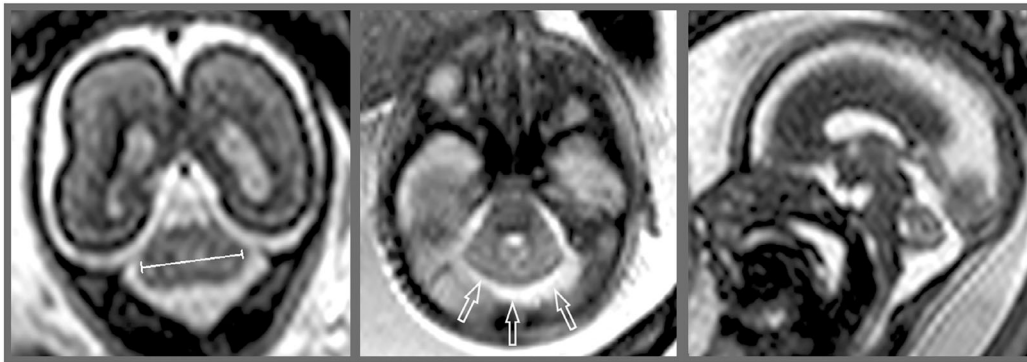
Rhombencephalosynapsis at 22 GW. (A) coronal T2-weighted image shows decreased transverse cerebellar diameter (line); (B) axial T2-weighted image shows convexity of the posterior cerebellar margin (arrows) due to absence of the vermis and vallicula; this feature, together with the abrupt angulation between the lateral and posterior cerebellar margins, generates a typical “bell-like” shape of the single-lobed cerebellum. (C) sagittal T2-weighted image shows absence of the primary fissure of the vermis, which should normally be visualized at this gestational age
